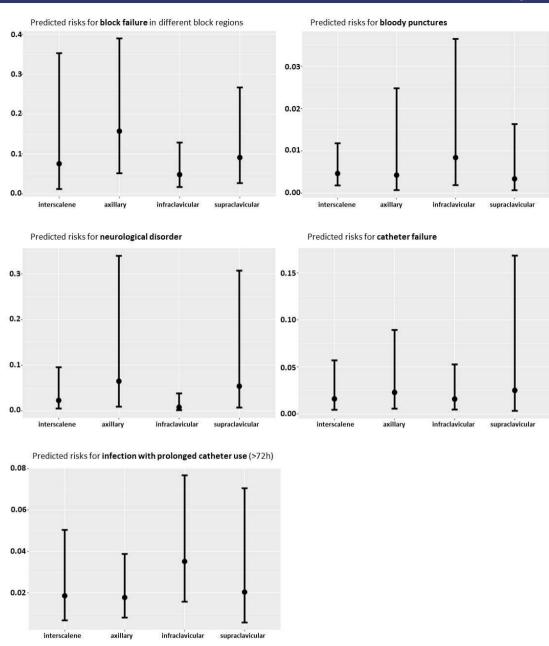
Predicted risks across different types of brachial plexus blocks for a sample patient representing an "median" healthy person from our study population undergoing ultrasound-guided brachial plexus block in 2022. The sample patient has the following characteristics: male sex, 56 years old, American Society of Anesthesiologists status ≤ 2 , body mass index ≤ 30 , catheter use, preoperative antibiotic prophylaxis, no multiple skin puncture during block implementation, no comorbidities such as diabetes, preoperative infection, immunosuppression, antithrombotic therapy.
